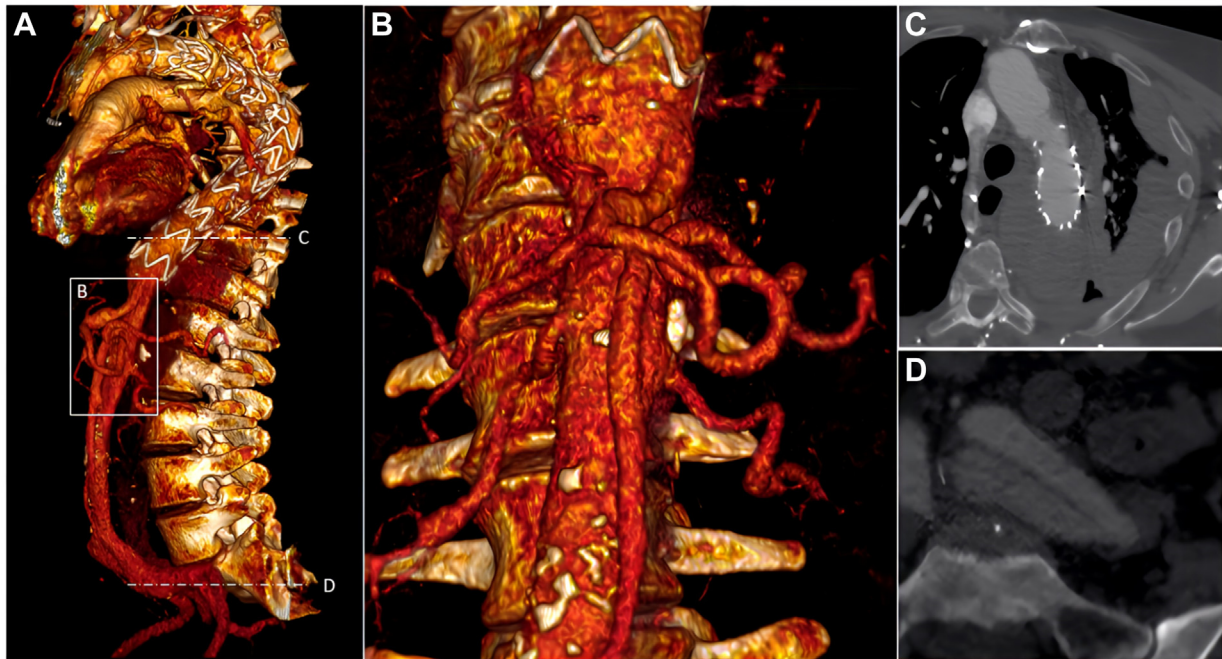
Preoperative computed tomography angiography (CTA) assessment of the aortic topology of the Patient. A, Aortic volume rendering reconstruction of the entire aorta; B, Volume rendering reconstruction of distal aorta showing visceral arteries origin from the true lumen; C, Axial section CTA showing a massive pleural effusion; D, Axial section CTA demonstrating the dissection of the left common iliac artery.
